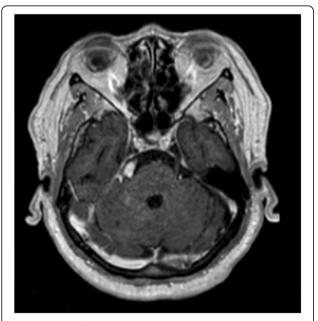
Posterior fossa MR imaging of the right trigeminal neuralgia patient. The lesion on the right side of the V. nerve (possibly vascular structure) is visible. This structure during surgery has been found to be compatible with the superior cerebellar artery
